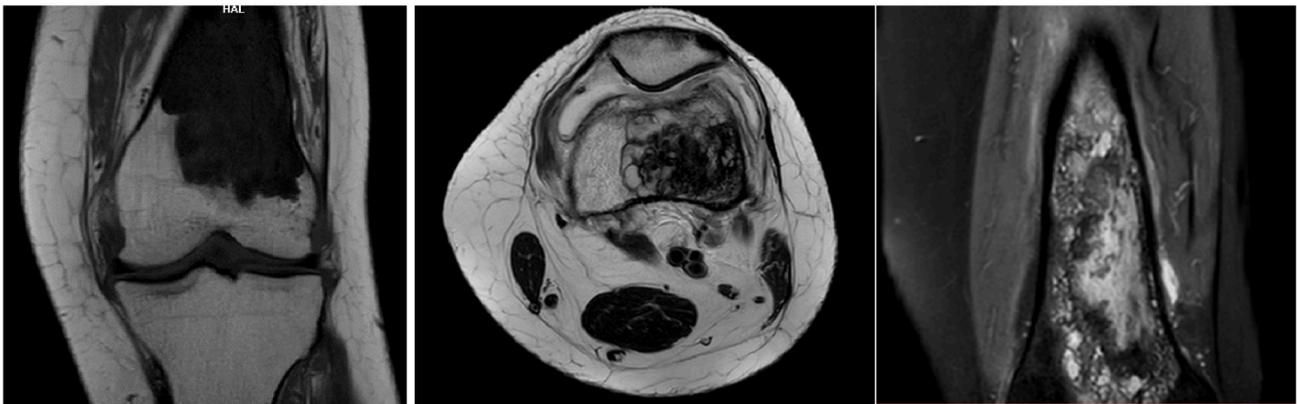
MRI images showing the lesion from left to right: T1 weighted image, T2 weighted image, PD weighted image.
